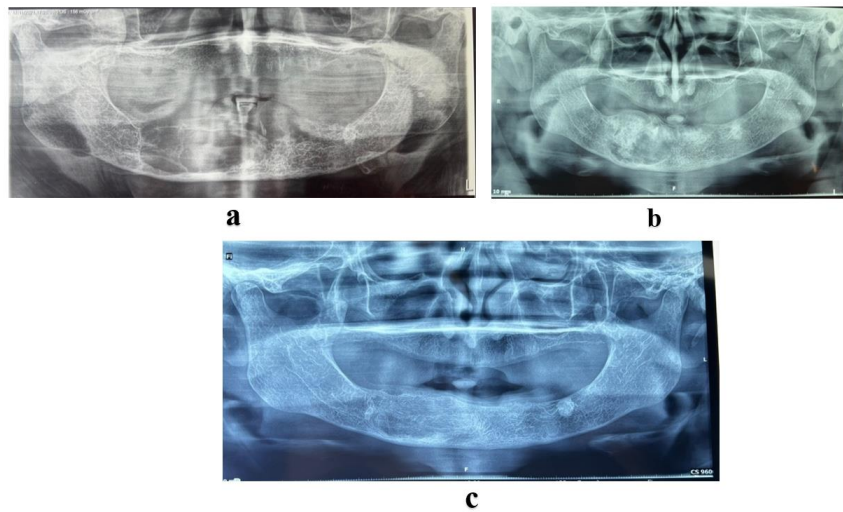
a: Initial panoramic radiograph; b: Panoramic radiograph in 2022; c: Orthopantomogram at 5 years showing a complete healing of the bony lesion
